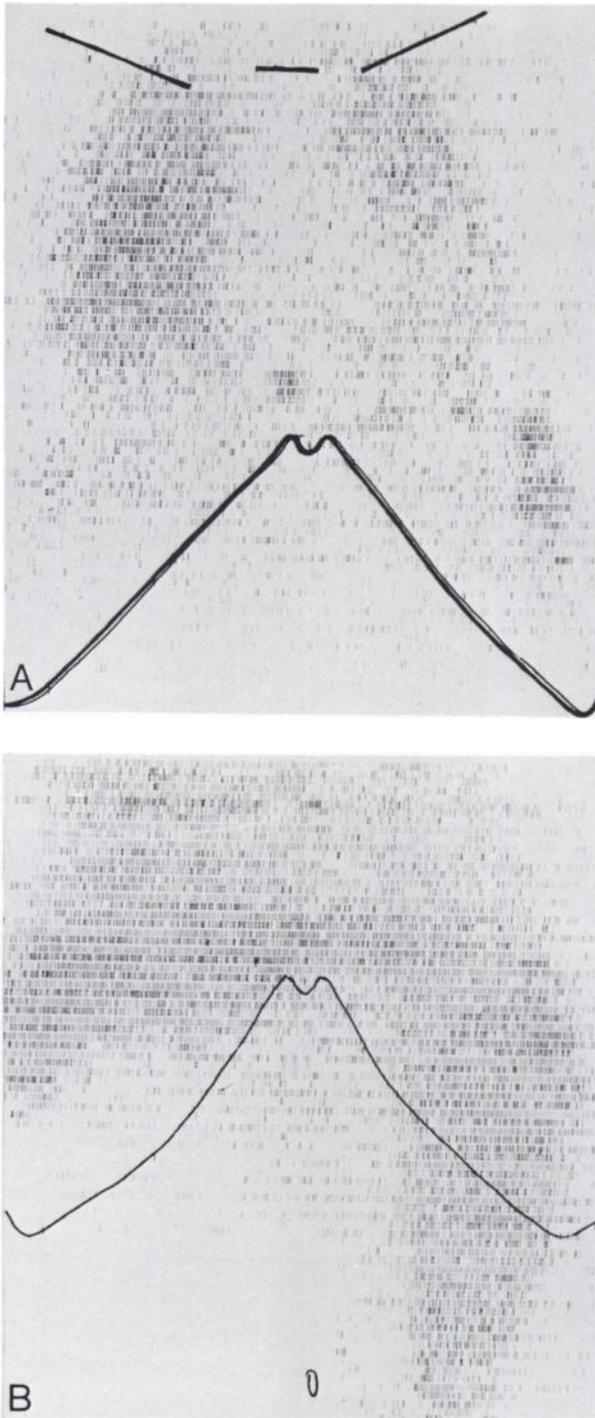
Splenoportoscintigram in case of thrombosis of v. lienalis. A is MAA scintigram (intrasplenic injection); in addition to intrasplenic tracer depot accumulation of tracer is demonstrated almost exclusively in lungs. No MAA particles can reach hepatic capillary network of portal vein since v. lienalis is completely occluded. B is ¹⁹⁹Au scintigram (i.v. injection); in contrast to A, it shows normal-shaped liver and grossly-enlarged spleen.
